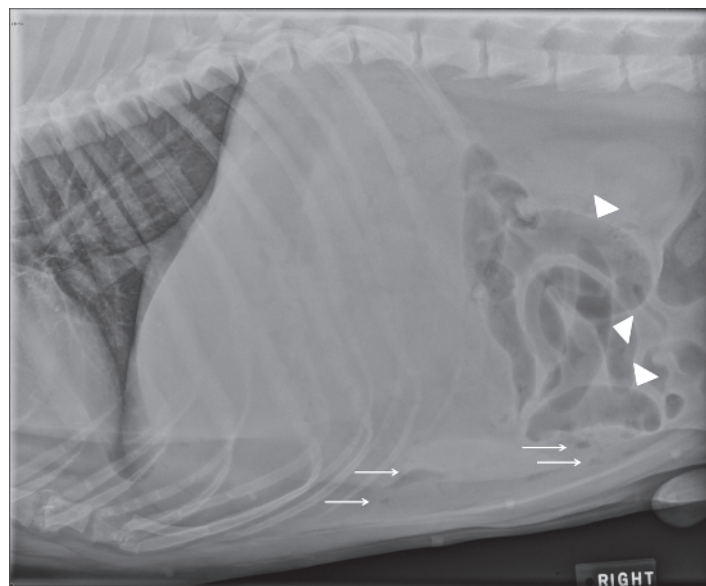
GI Septic peritonitis with free gas. Lateral radiograph from a 6-year-old Labrador Retriever with septic peritonitis. Note the multiple small gas bubbles in the ventral aspect of the abdomen (arrows). Loss of serosal detail is also present. Some loops of bowel in the mid-ventral abdomen are gas distended (arrowheads) (courtesy Dr. Robert O'Brien, DVM, DACVS).
